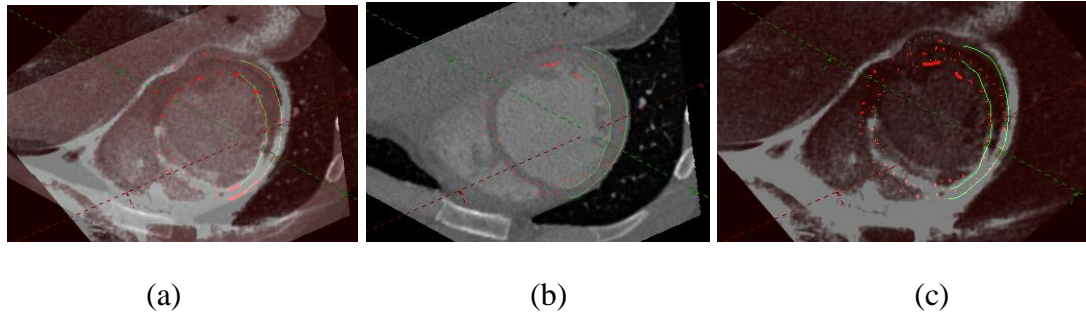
Résultat final de recalage pour le patient 1 : les deux volumes superposés (a), CT (b) et IRM-RT (c).
